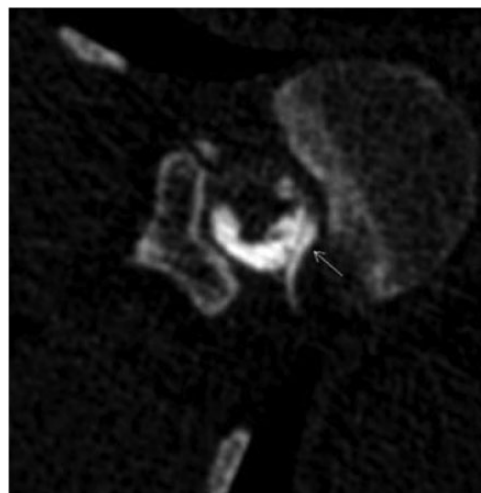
Dynamic CT myelography at T12-L1 level showing contrast leak
